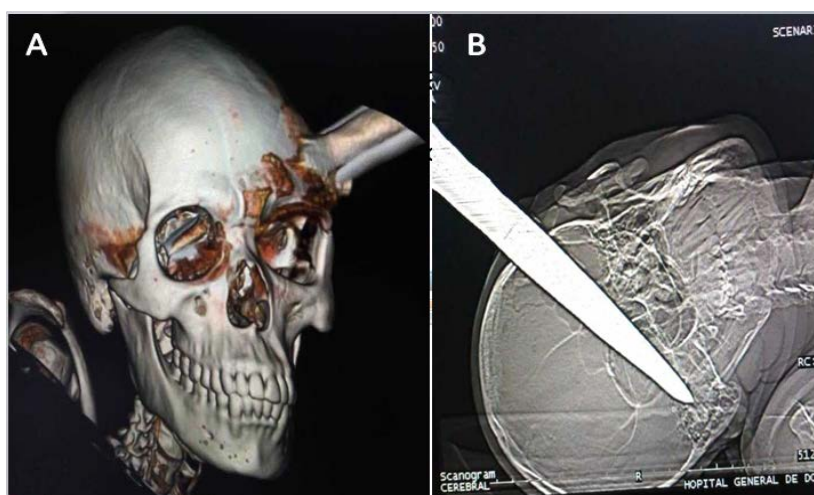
Head CT-Scan showing the penetrating brain injury by the pickaxe. Frontal reconstructive view (A). Coronal reconstructive view (B).
